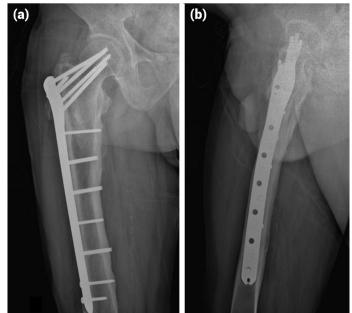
AP and Lateral r X-RAY views of PERI-LOC® PFLCP.
